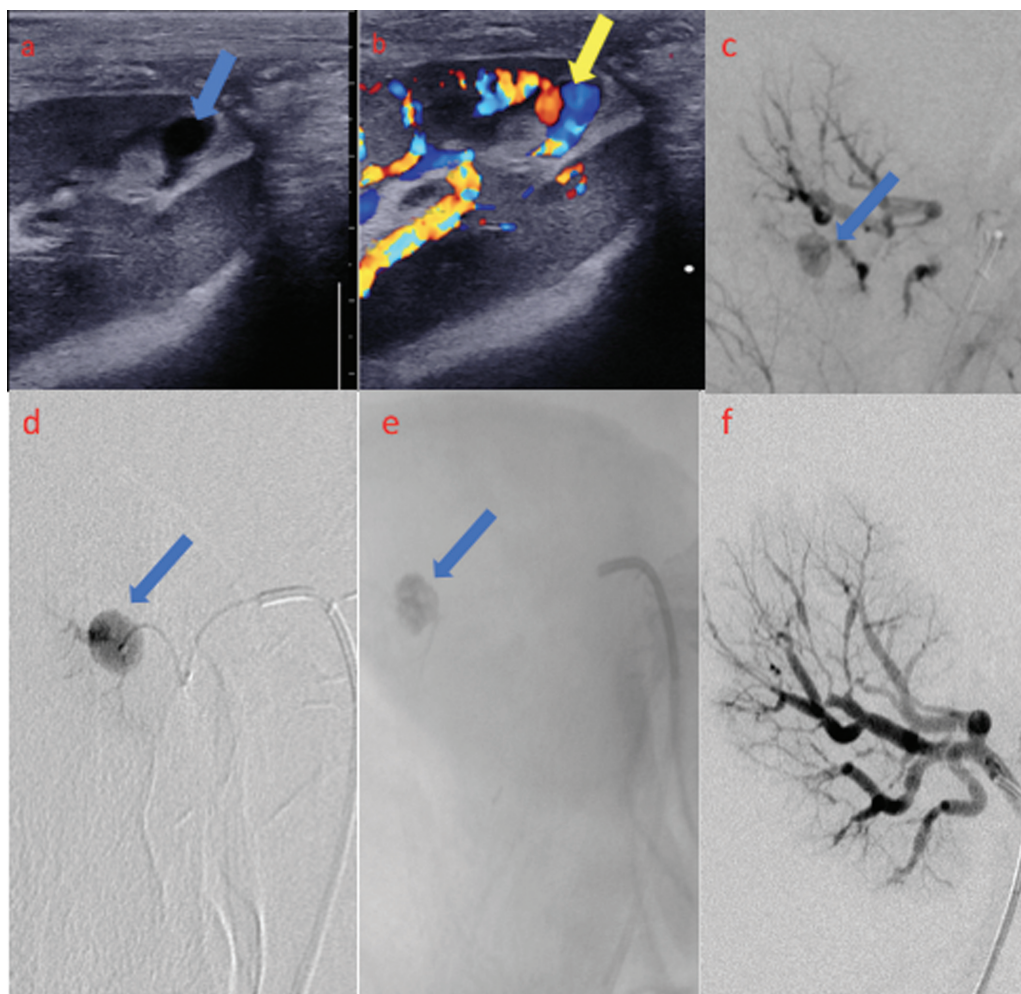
USG (a) and (b), 2D and Doppler images of transplanted kidney show well-defined saccular outpouching (blue arrow) in the arcuate branch of the lower pole of transplant kidney with classical “yin –yang” sign (yellow arrow). The pseudoaneurysm is visible on the DSA (c) (blue arrow). Superselective catheterization of the pseudoaneurysm branch and embolisation with 50% NBCA glue (d and e). Postembolisation DSA (f) showed complete obliteration of the pseudoaneurysm. DSA, digital subtraction angiography; NBCA, N-butyl cyanoacrylate.
